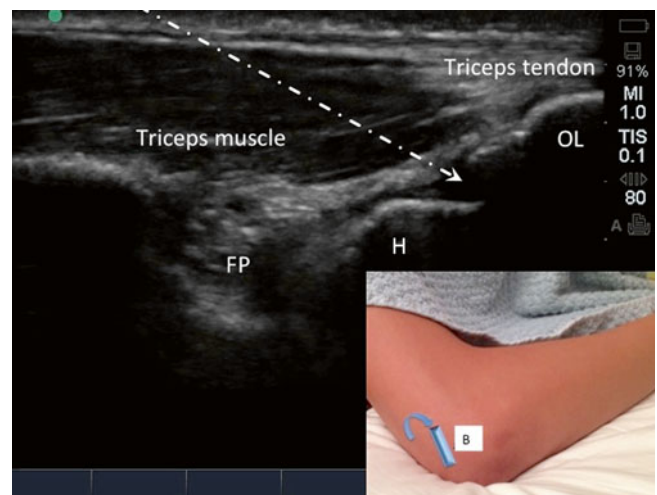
Sonogram of the elbow joint as in Fig. 36.7 except that the ultrasound probe is rotated as shown in the inset. The dotted arrow indicates the needle insertion into the elbow joint. FP fat pad; H humerus; OL olecranon (Reproduced with permission from Philip Peng Educational Series)
